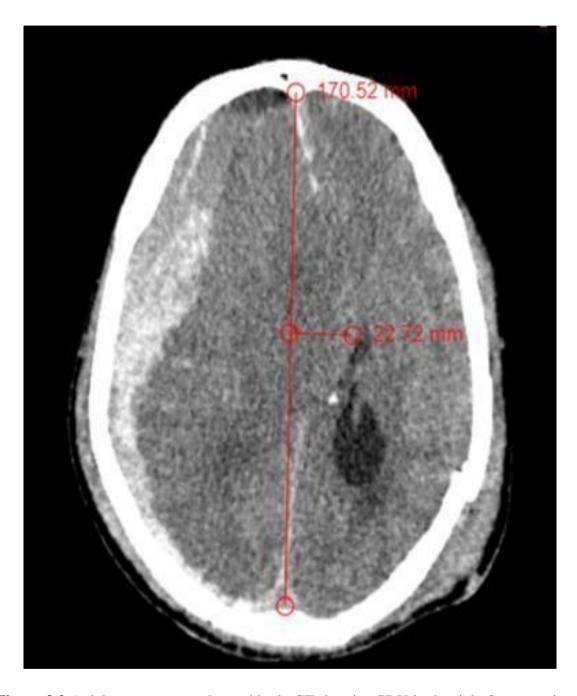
Axial non contrast enhanced brain CT showing SDH in the right fronto-parieto-temporal lobe with effacement of the ipsilateral lateral ventricle causing midline shift of 22.7 mm to left and SAH
